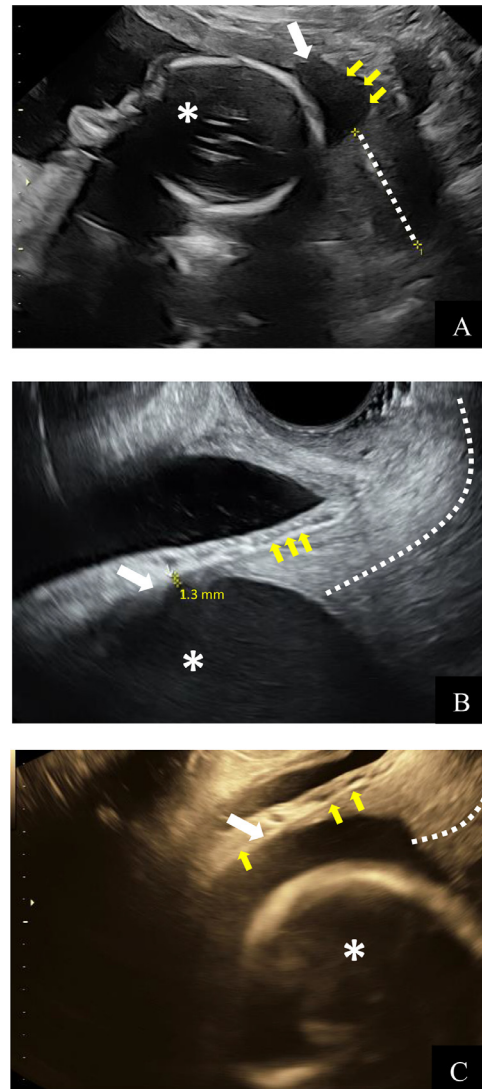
Transabdominal (A) 2D ultrasound of the presenting fetus at 23w6d demonstrating fetal head (asterisk), lower uterine segment bulge (yellow arrows), cervical canal (dotted white line), and location of myometrial thinning (white arrow). Transvaginal ultrasound (B) of the cervix, lower uterine segment, partially distended maternal bladder, and twin pregnancy at 22w6d. The white dotted line indicates the endocervical canal, the yellow arrows indicate the outer margin of the bladder serosa, and the white arrow indicates the thinnest portion of the lower uterine segment myometrium which measures 1.3 mm as indicated by the yellow caliber. Amniotic fluid without fetal presenting parts is visible (star). (C) Transvaginal ultrasound performed at 23w6d fetus with fetal head (asterisk) as the presenting part. Volume contrast imaging technique permits improved resolution of solid organ boundaries between the bladder wall and substantially thinned lower uterine segment myometrium. The yellow arrows indicate the distal margin of the maternal bladder, with the white arrow highlighting the proximal most region of nonvisualized myometrium. The dotted white line delineates the cervical canal.
